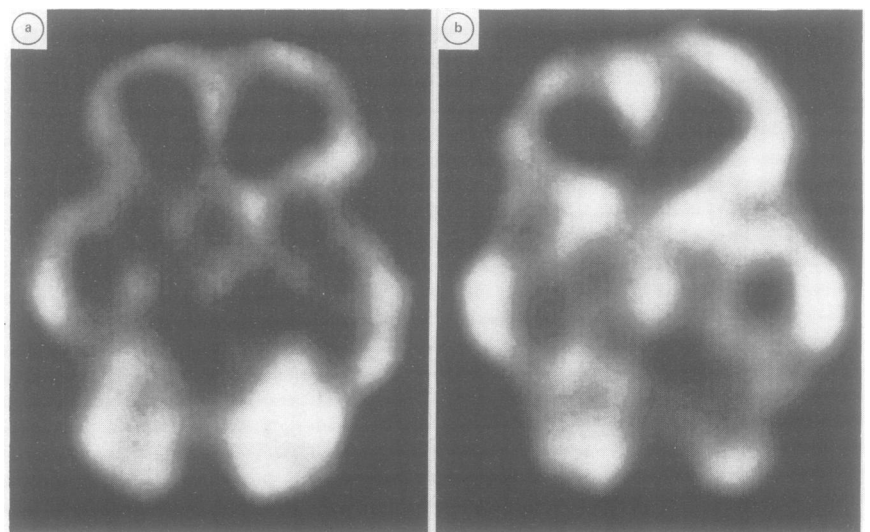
(a) Original ictal SPECT showing hyperperfusion of the left cerebellar hemisphere. (b) Recent interictal SPECT showing hypoperfusion of the left cerebellar hemisphere, corresponding closely with the originally hyperperfused area.
